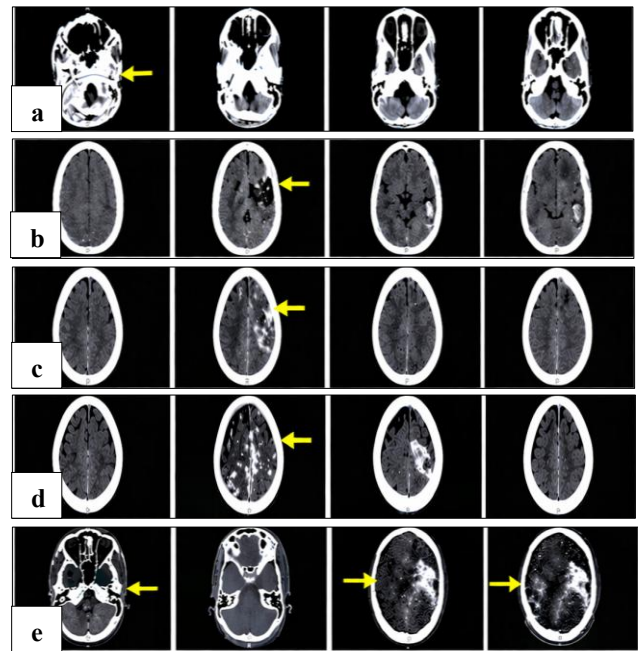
Non-contrast computed tomographic results, (a) left frontal linear undisplaced skull fracture, (b) left-sided epidural hematoma, (c) left intraparenchymal haemorrhage, (d) multiple hemorrhagic contusions, and (e) combined traumatic findings with mass effect.
